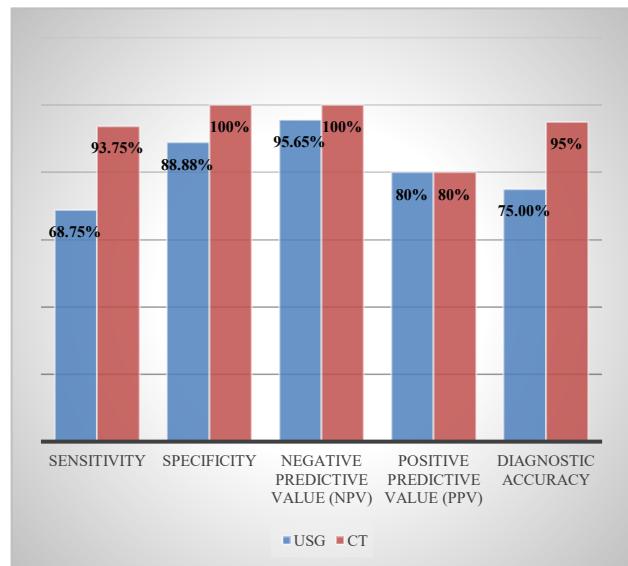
Comparison of sensitivity, specificity, and predictive values of USG and CT in evaluating calculus obstructive uropathy.
